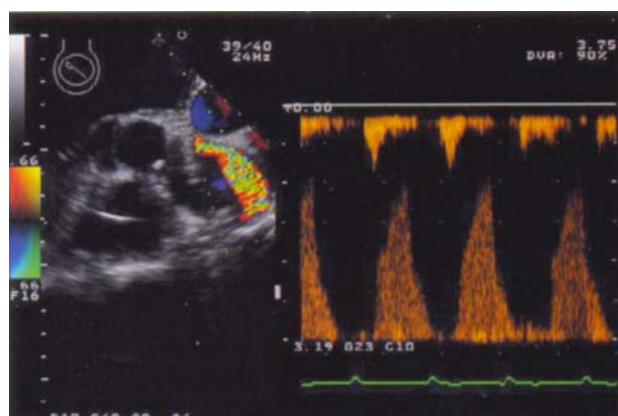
Outflow cannula of a pulsatile left ventricular assist device (LVAD) positioned in the ascending aorta, imaged in the mid-oesophageal long-axis view. Colour flow Doppler shows turbulent flow, and continuous wave Doppler shows unobstructed pulsatile flow with a maximum velocity of 2 m/s.
